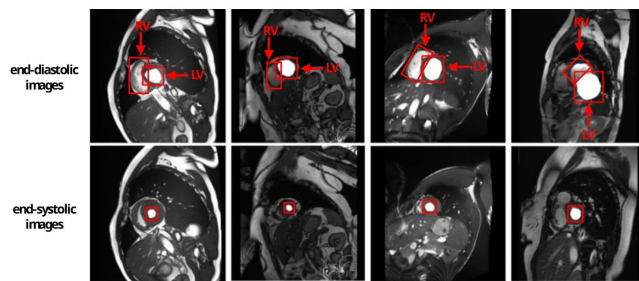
Cine-MRI Scans Images Samples from ACDC Dataset
